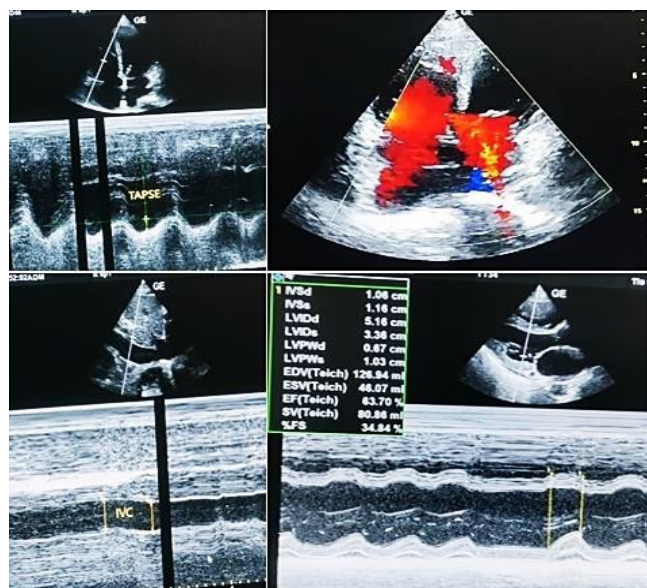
Results of the patient's transthoracic echocardiography as a diagnostic modality
